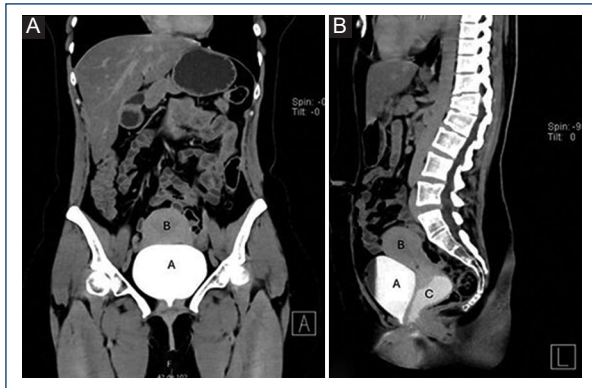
CT urography in coronal A the entire bladder A: is observed in the elimination phase with the proximal urethra above the uterus B: urography in sagittal we observe the bladder (A) above this the uterus (B) in the usual way, on the left side of the image we observe the vagina (C) in which there is passage of contrast medium from the urethra in dorsal decubitus position showing the deficiency of the urethra to retain urine.
